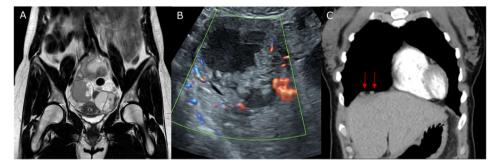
A) Pelvic MRI showing bilateral complex masses with solid and cystic components B) Transvaginal ultrasound demonstrating a multiseptated cystic mass of the right ovary with abundant solid areas and color flow C) Chest CT showing several prominent cardiophrenic lymph nodes measuring up to  $14 \times 9$  mm.
